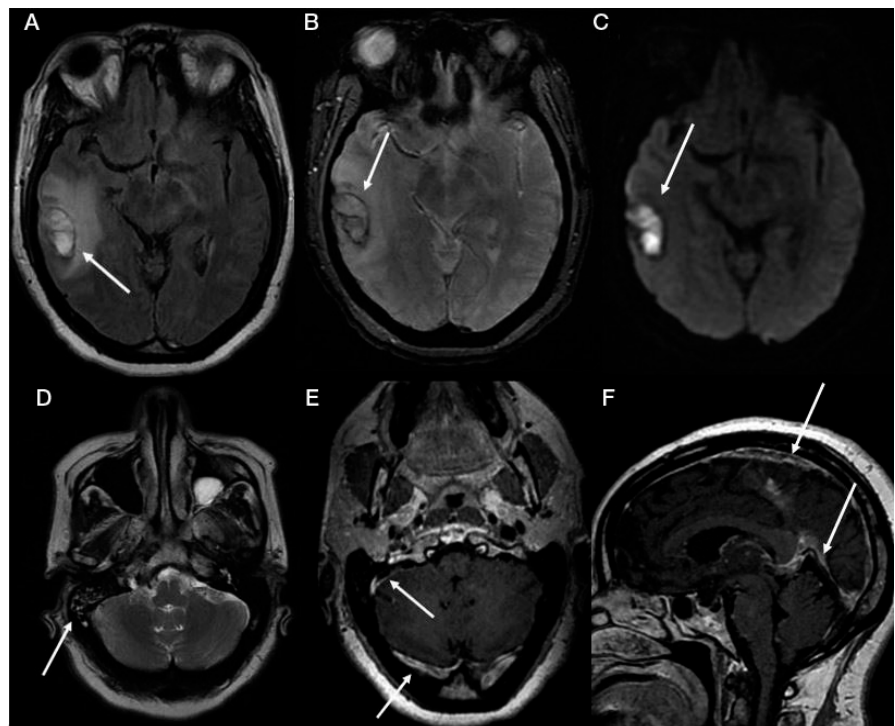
Magnetic resonance imaging results of a 56-year-old woman from Brazil after she developed a right-side hemiparesis, dysarthria, and fever. (A) Axial fluid-attenuated inversion recovery reveals an ovoid hemorrhagic lesion surrounded by an area of vasogenic edema in the temporal lobe (arrow); (B) Axial gradient-echo confirms the presence of peripheral hemosiderin surrounding the temporal hematoma (arrow); (C) Axial diffusion-weighted imaging shows central hyperintensity related to blood susceptibility artifact (arrow); (D) Axial T2W image shows fluid in the mastoid cells related to mastoiditis (arrow); (E) Post-contrast axial T1W reveals thrombosis of the transverse and sigmoid sinuses (arrows); (F) Post-contrast sagittal T1 shows thrombosis of the straight and superior sagittal sinuses (arrows).
